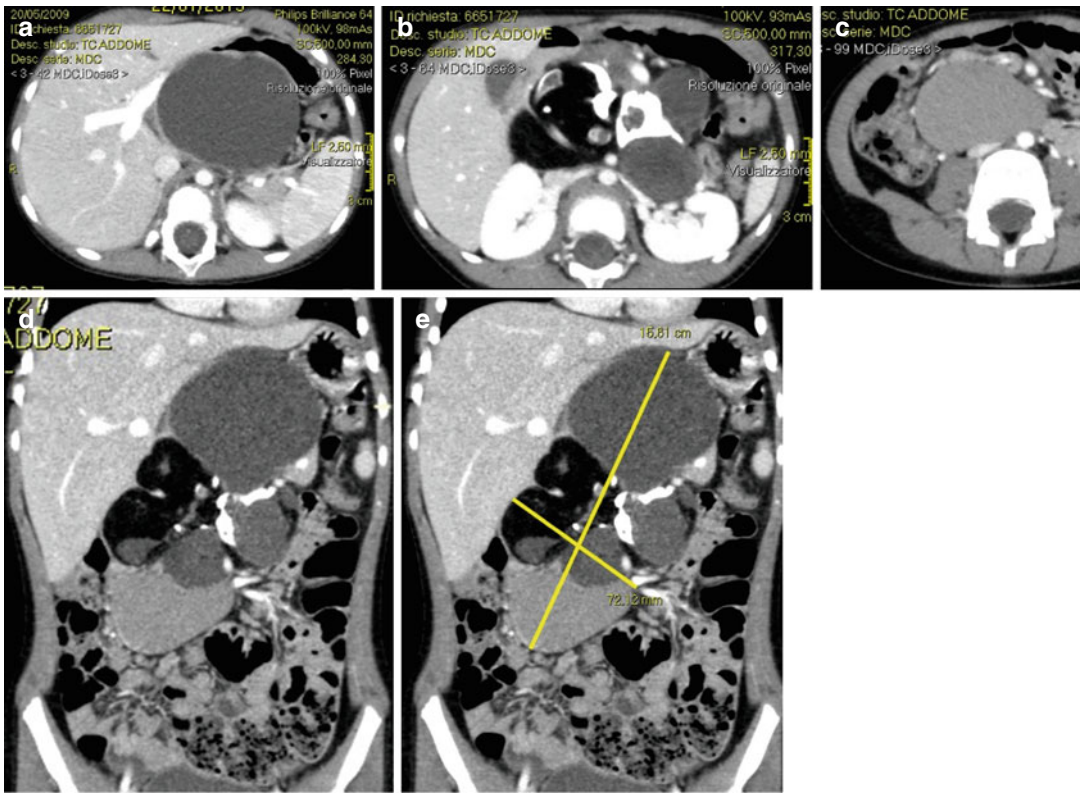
Contrast-enhanced axial CT (a–c) and MPR coronal reconstructions (d, e) well demonstrate the large retroperitoneal mature cystic teratoma with its different components
